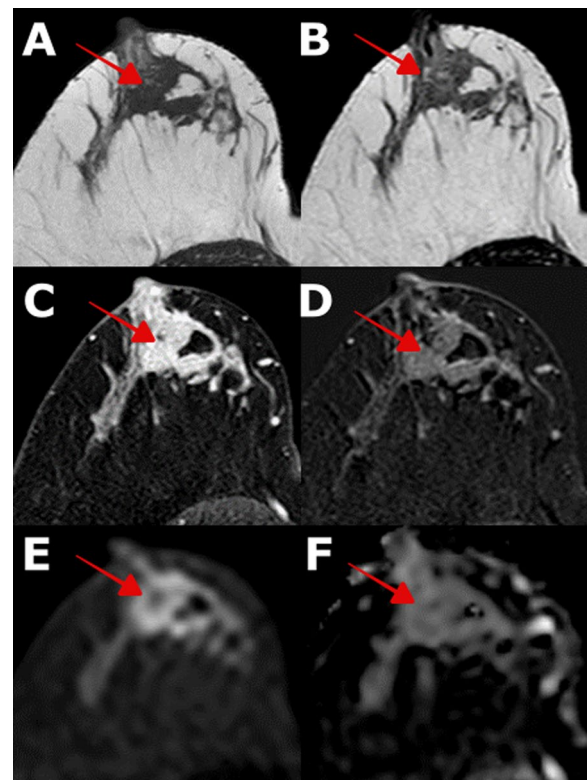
Female patient aged 28 years old complaining of right breast lump with no family history of breast cancer. MRI revealed: A & B Pre-contrast T1- and T2-weighted axial image showing: large mass with irregular margin seen at the inner half of the right breast infiltrating the nipple-areolar complex. C & D Post-contrast dynamic and subtraction axial images showing: a large heterogeneous enhancing mass seen at the inner half of the right breast infiltrating the nipple-areolar complex with related medially located segmental non-mass enhancement. E & F DWI shows high signal intensity with low signal in ADC map with mean lesion ADC value = $0.9 \times 10^{-3} \text{ mm}^2/\text{sec}$ and perilesional ADC = $1.18 \times 10^{-3} \text{ mm}^2/\text{sec}$. Pathology proved to be Grade III invasive duct carcinoma associated with extensive high-grade ductal carcinoma in situ—HER2 subtype—Ki-30%
